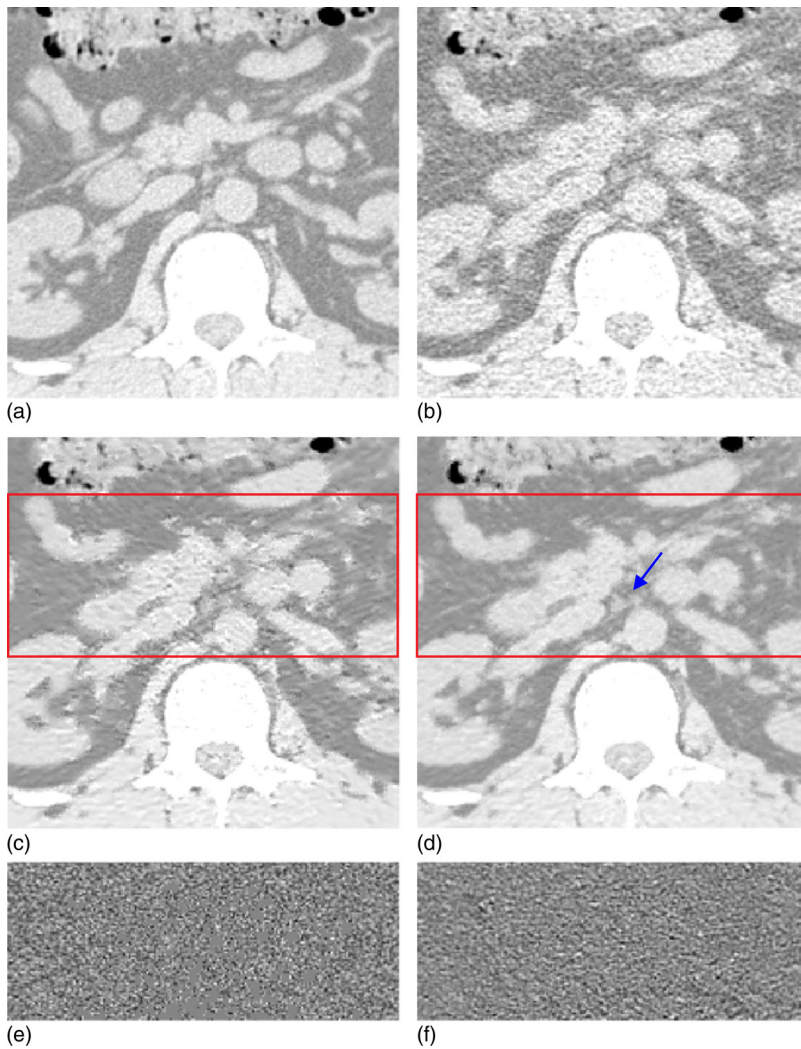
Zoomed abdominal CT images corresponding to Fig. 8: (a) the normal-dose scan; (b) the low-dose scan; (c) the restored image from the low-dose scan by the NLM algorithm; (d) the restored image from the low-dose scan by the ndiNLM algorithm; (e) the corresponding difference ROI image, indicated by the red square in (c), from (c) and (b); and (f) the corresponding difference ROI image, indicated by the square ROI in (d), from (d) and (b). Display window option: width is 545 HU, level is  $-169$  HU.
